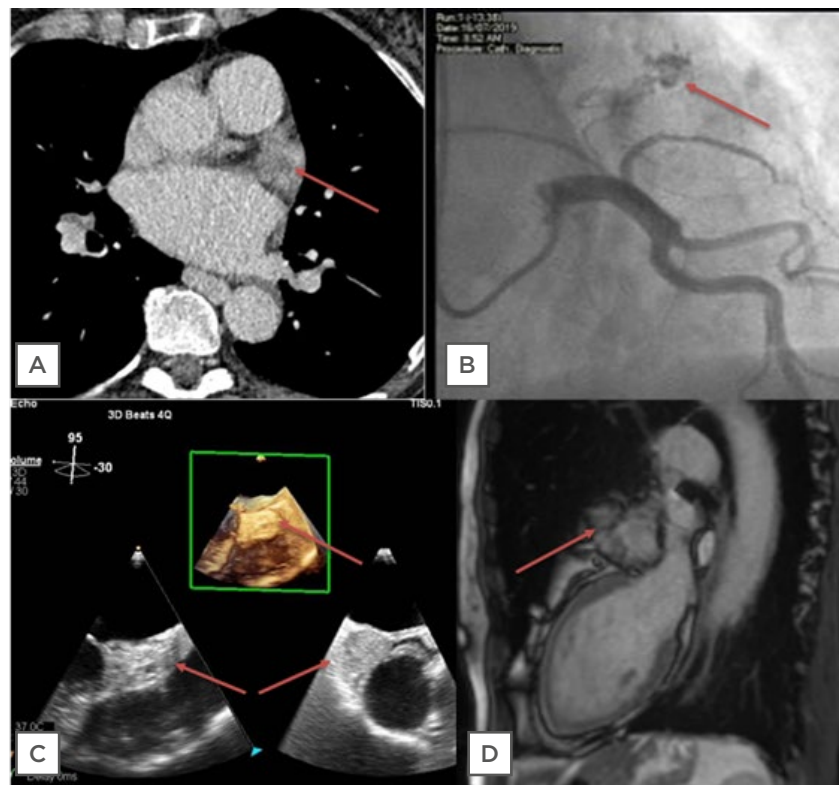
Imaging modalities, with cardiac mass highlighted by red arrow. A) Transverse section on CT; B) right anterior oblique cranial view on angiography showing neovascular formation supplying haemangioma; C) transoesophageal echocardiography with 3D imaging showing a left atrium mass; D) sagittal section on cardiac MRI.
